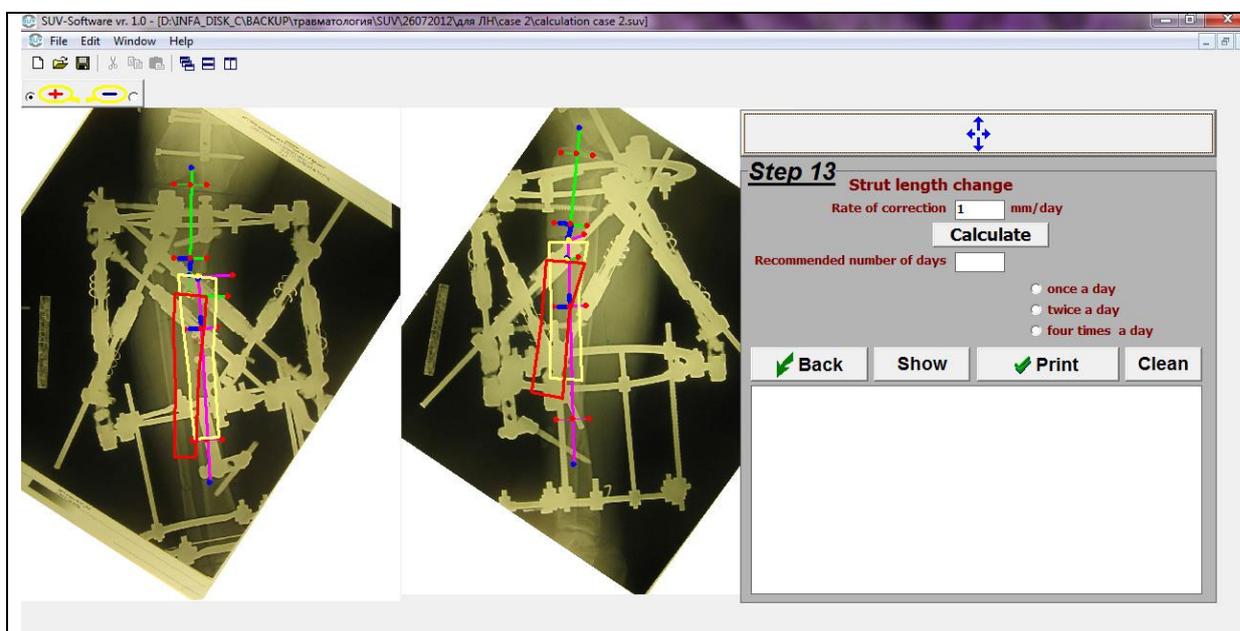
Ortho-SUV program window in Step 13: choice of rate of correction. The deformity correction rate has been entered: 1 mm/day
